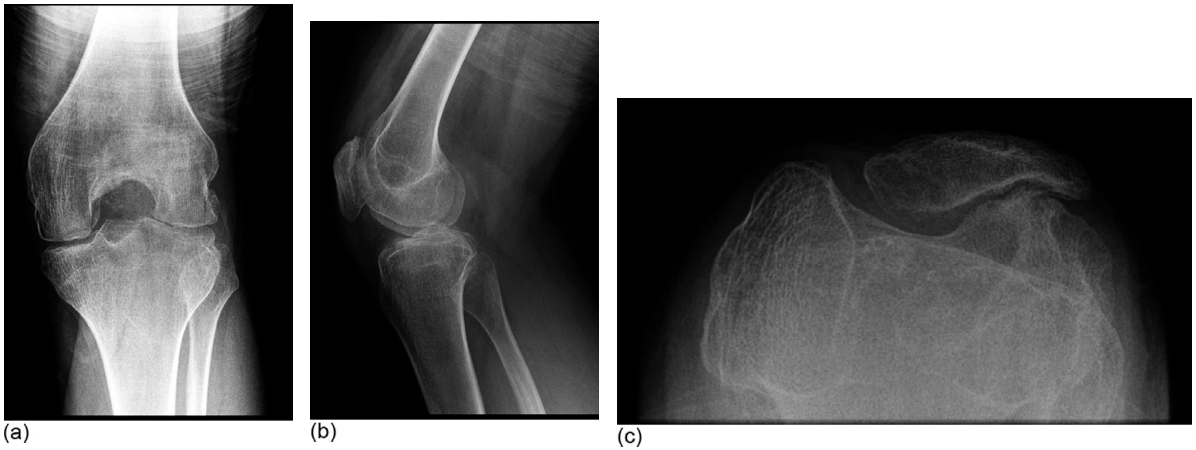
Radiographs knee. (a) Anteroposterior (AP) widened intercondylar notch, flattened condylar surfaces; (b) lateral squared inferior margin of the patella; and (c) patella
